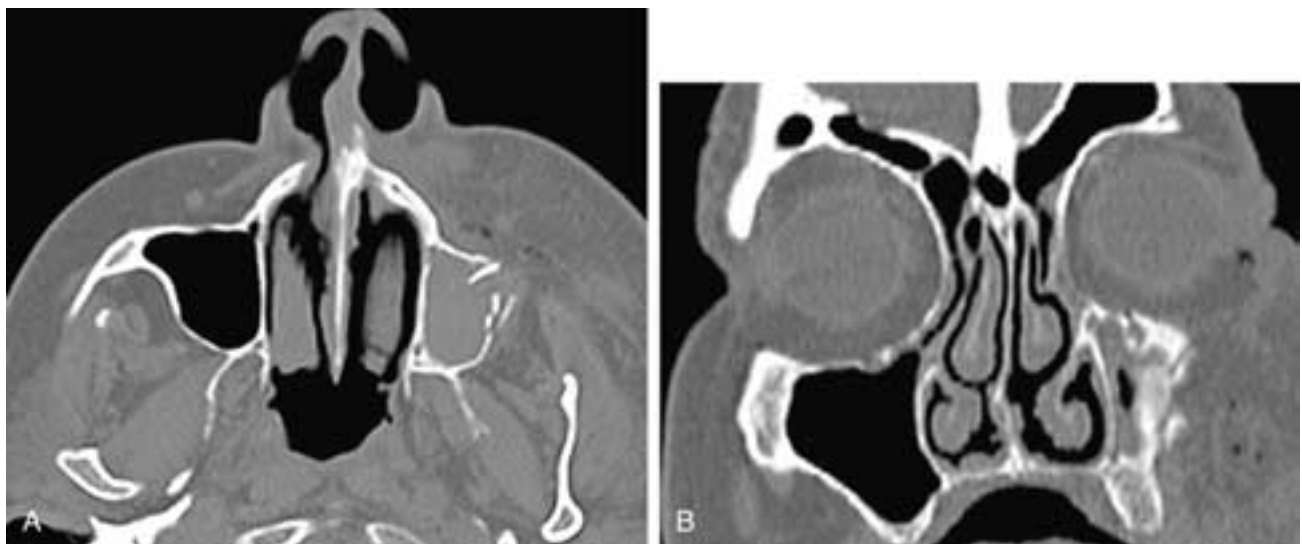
Axial (A) and Coronal (B) CT scans show a comminuted fracture of the anterolateral left antral wall. This type of fracture usually is the result of a blow from a narrow object.
